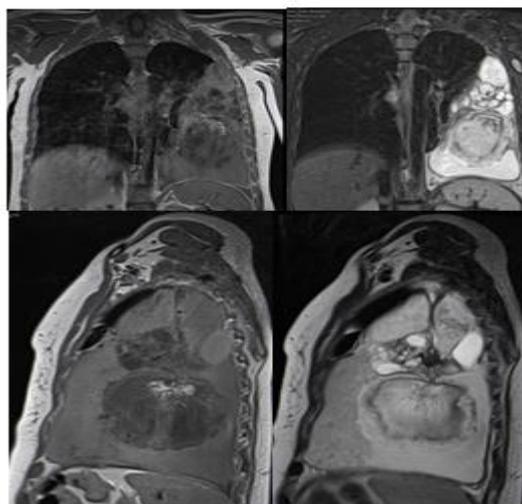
Thoracic MRI showing a heterogeneous left pleural lesion, bilobed, with triple component (tissue, fat and calcification), the tissular part is iso intense in T1, hyper intense in T2 and diffusion with a restricted ADC
